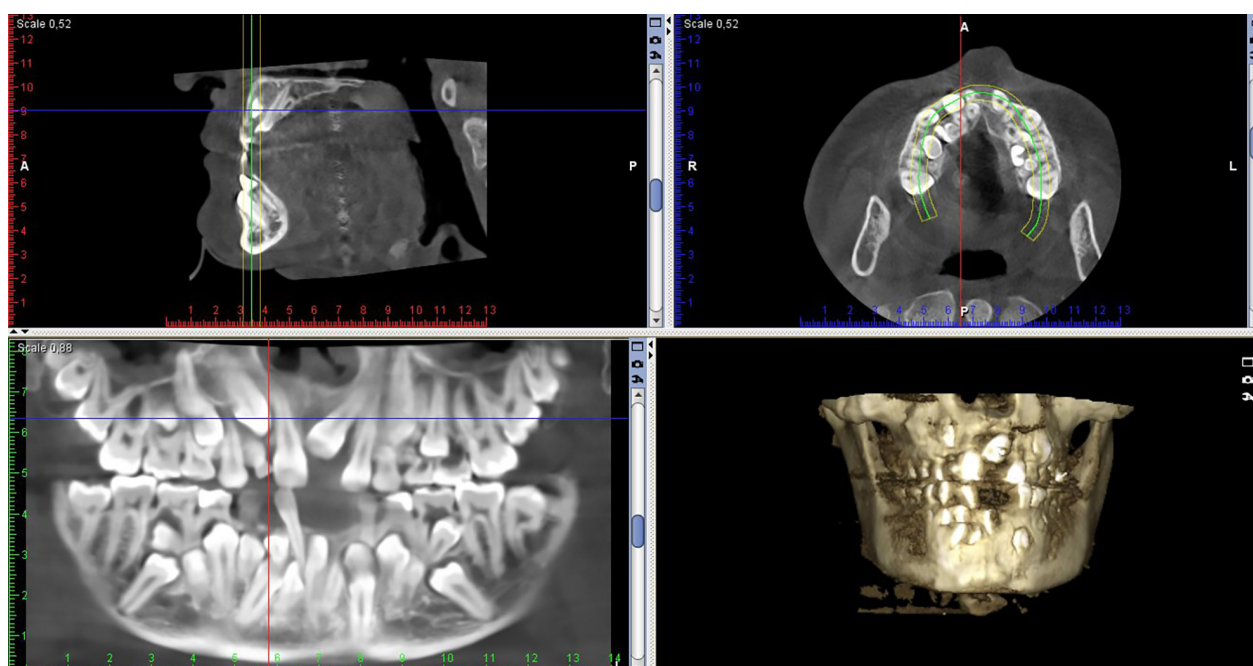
CBCT on patient P.K. in 2022.
